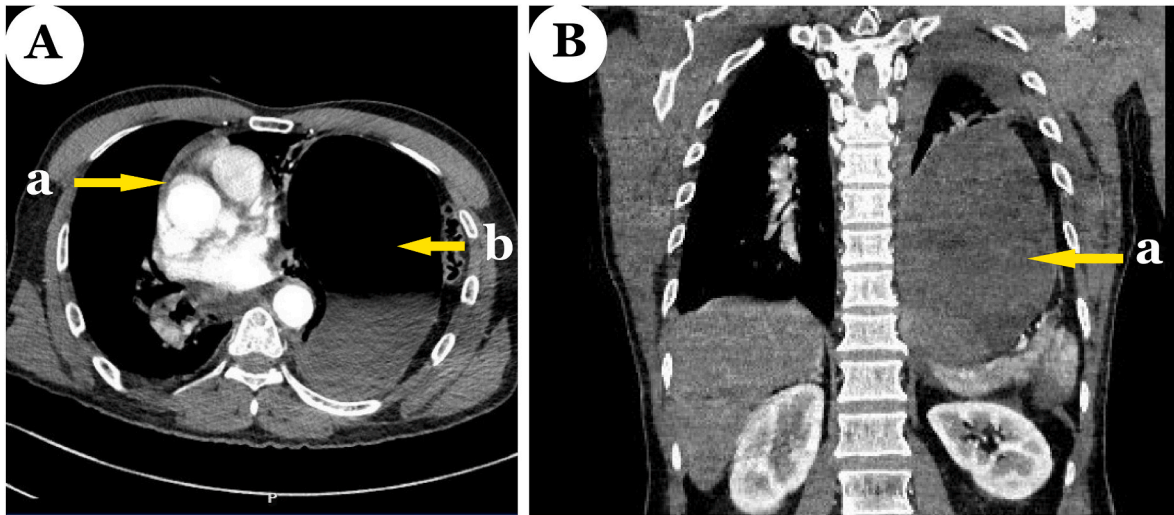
Intra-abdominal organs are herniated into the pleural cavity via the left diaphragmatic tear (A-b, B-a) and aortic rupture (A-a) with an axial (A) and coronal (B) computed tomography (CT) scan image.
